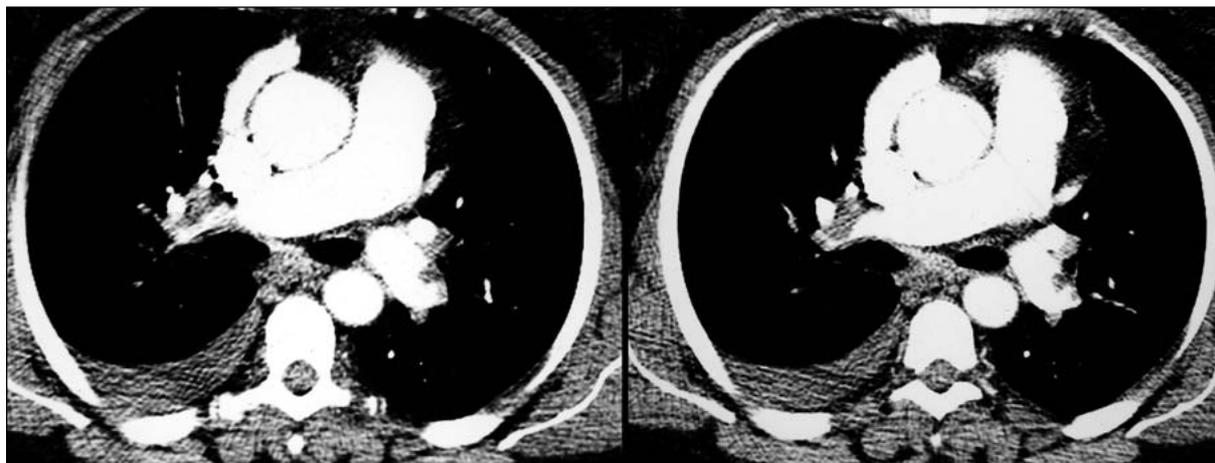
Computed tomography angiography; large intraluminal filling defects.
